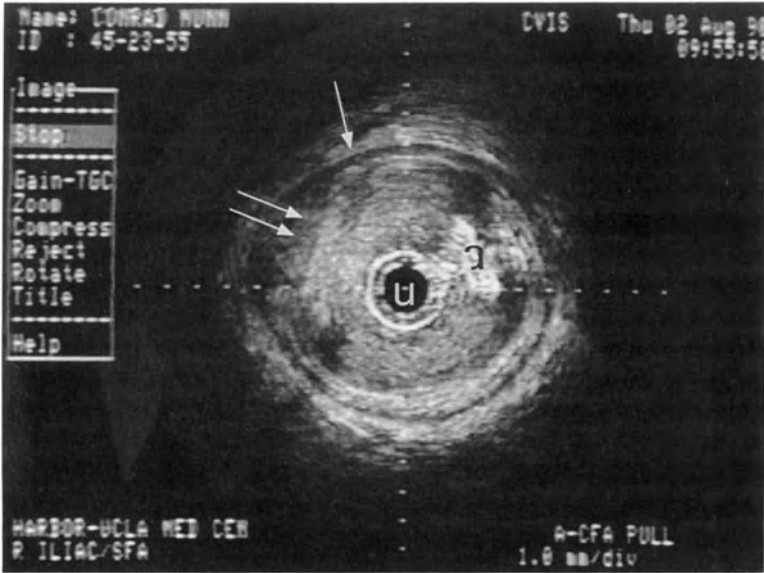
Intravascular ultrasound imaging of a human iliac artery using an 8 Fr catheter. U, ultrasound probe; single arrow, normal 3-layer muscular artery wall; double arrow, soft plaque or thrombus. Shadow, a, is an artifact produced by a thin metallic wire along the axis of a catheter.
